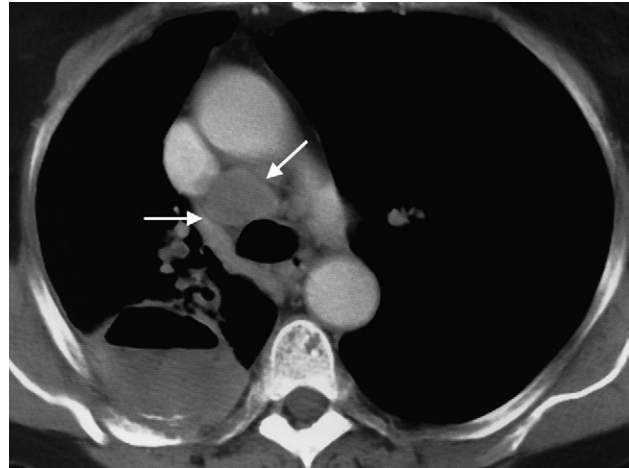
CT scan of a greatly enlarged lymph node (arrows). Note that the primary tumour lying posteriorly in the right lung has invaded the chest wall and partially destroyed the adjacent rib.
